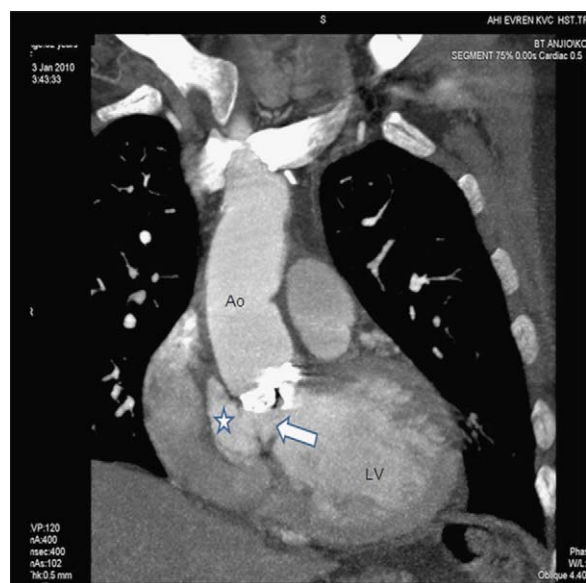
Cardiac multidetector computed tomography (coronal image) shows pseudoaneurysm (asterisk) of left ventricular outflow tract. Note the pseudoaneurysm opens to the left ventricular outflow tract with a narrow neck (arrow). Ao, aorta; LV, left ventricle.
